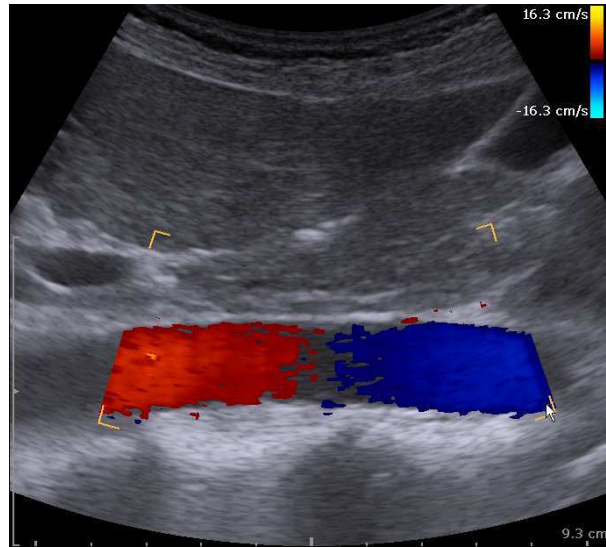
Conventional color Doppler ultrasound imposed on a b-mode image of the abdominal aorta in the longitudinal plane. There is no signal from the area in the center where the flow is directed perpendicular to the ultrasound beam ($\theta=90^\circ$).*
